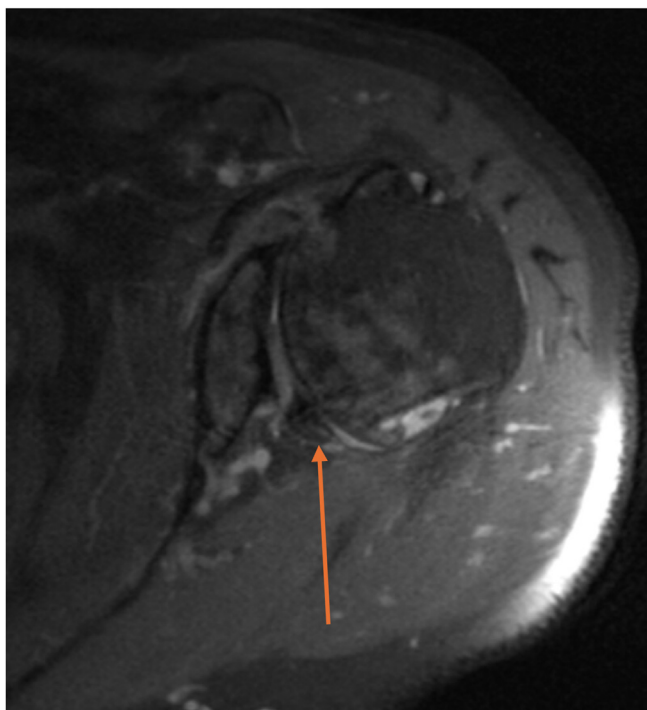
MRI of the left shoulder showing posterior labral hypertrophy (arrow) characteristic in glenoid hypoplasia. MRI, magnetic resonance imaging.
